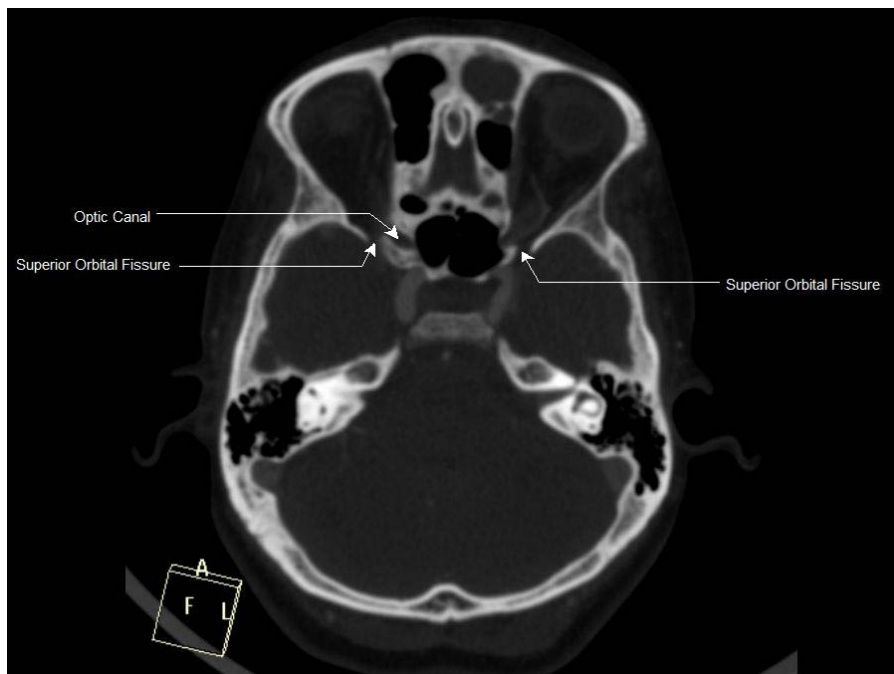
CT scan figure depicting optic foramen
